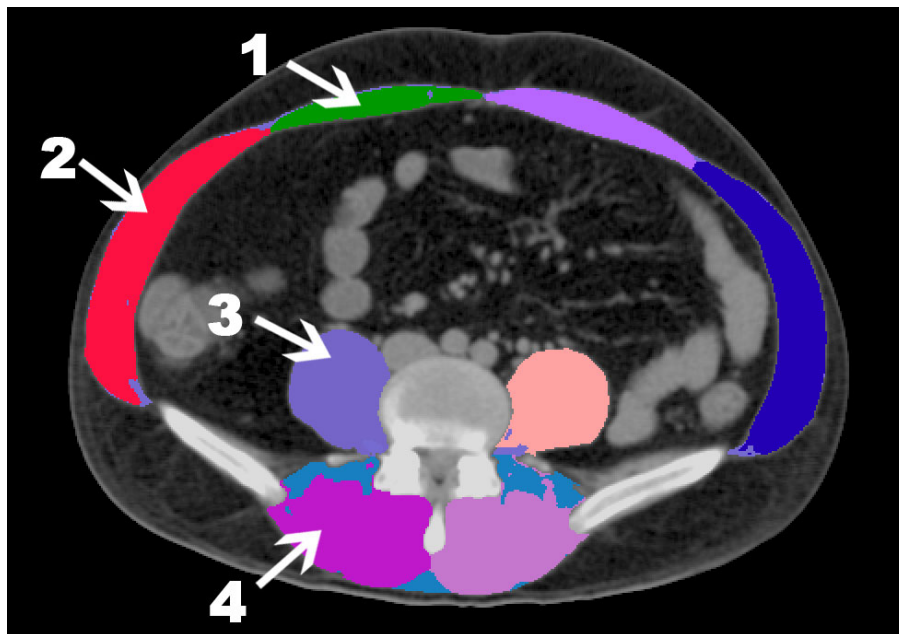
Axial computed tomography obtained at the L4-L5 region showing: 1) rectus abdominis muscle, 2) anterolateral abdominal muscles (external oblique, internal oblique and transversus abdominis), 3) psoas major muscle, and 4) paraspinal muscles (erector spinae and transversospinalis).
